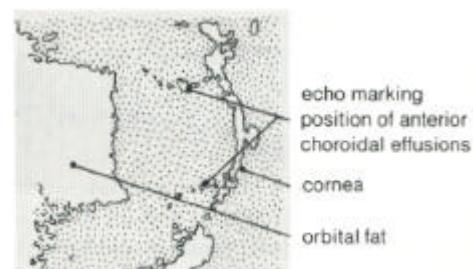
scan ultrasound of the same patient showing choroidal effusion. Management requires investigation for the cause of scleritis and anti-inflammatory therapy such as systemic nonsteroidal anti-inflammatory drugs or steroids. Treatment of the scleritis will be followed by spontaneous resolution of the effusions with deepening of the anterior chamber. Antiglaucoma therapy involves acetazolamide and topical beta-blockers for the raised intraocular pressure, and cycloplegics to dilate the pupil and deepen the anterior chamber, together with topical steroids. Should the angle remain closed for longer than a few days a laser iridotomy will help in limiting the development of peripheral anterior synechiae.
